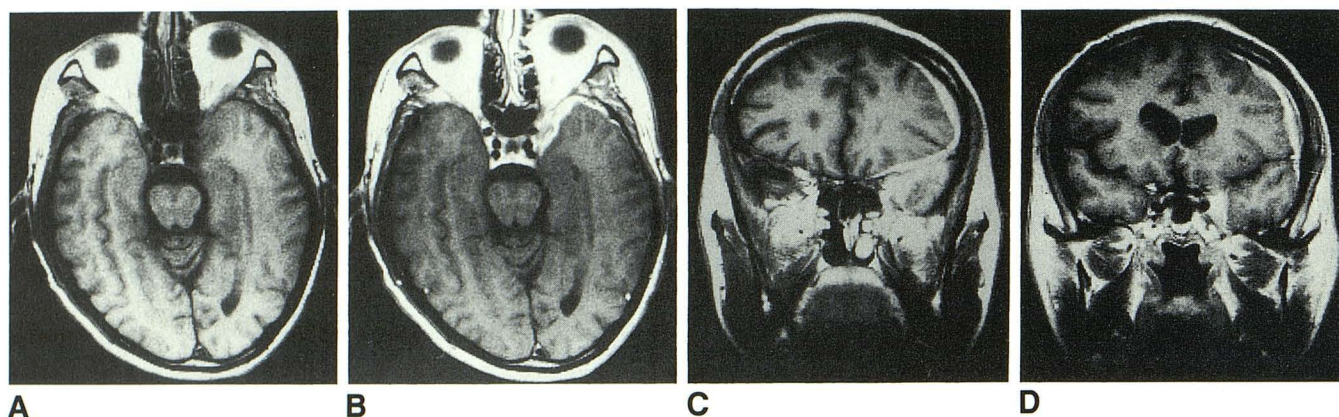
A, T1-weighted axial MR image (400/21) without contrast 2 months after symptom onset shows only asymmetry of left cavernous sinus. B, T1-weighted axial MR image (400/21) after injection of gadopentetate dimeglumine shows large extension to temporal convexity. C and D, T1-weighted coronal MR images (400/21) show large extension to frontal and temporal convexities.
